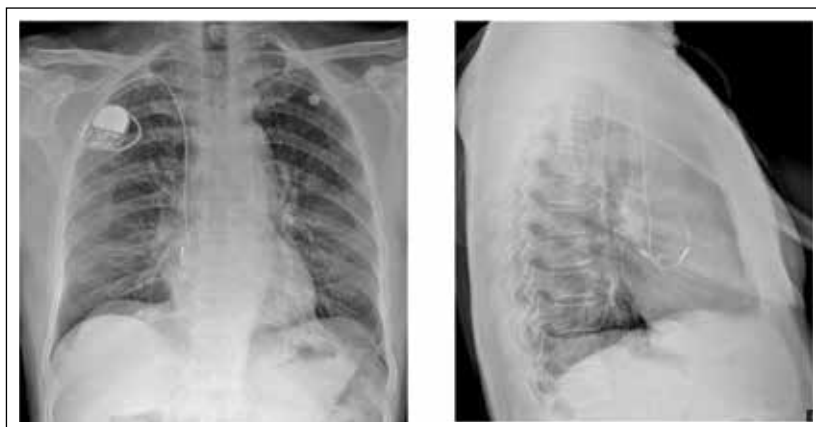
Tined lead in the RA appendage seen in frontal chest radiograph and lateral film
